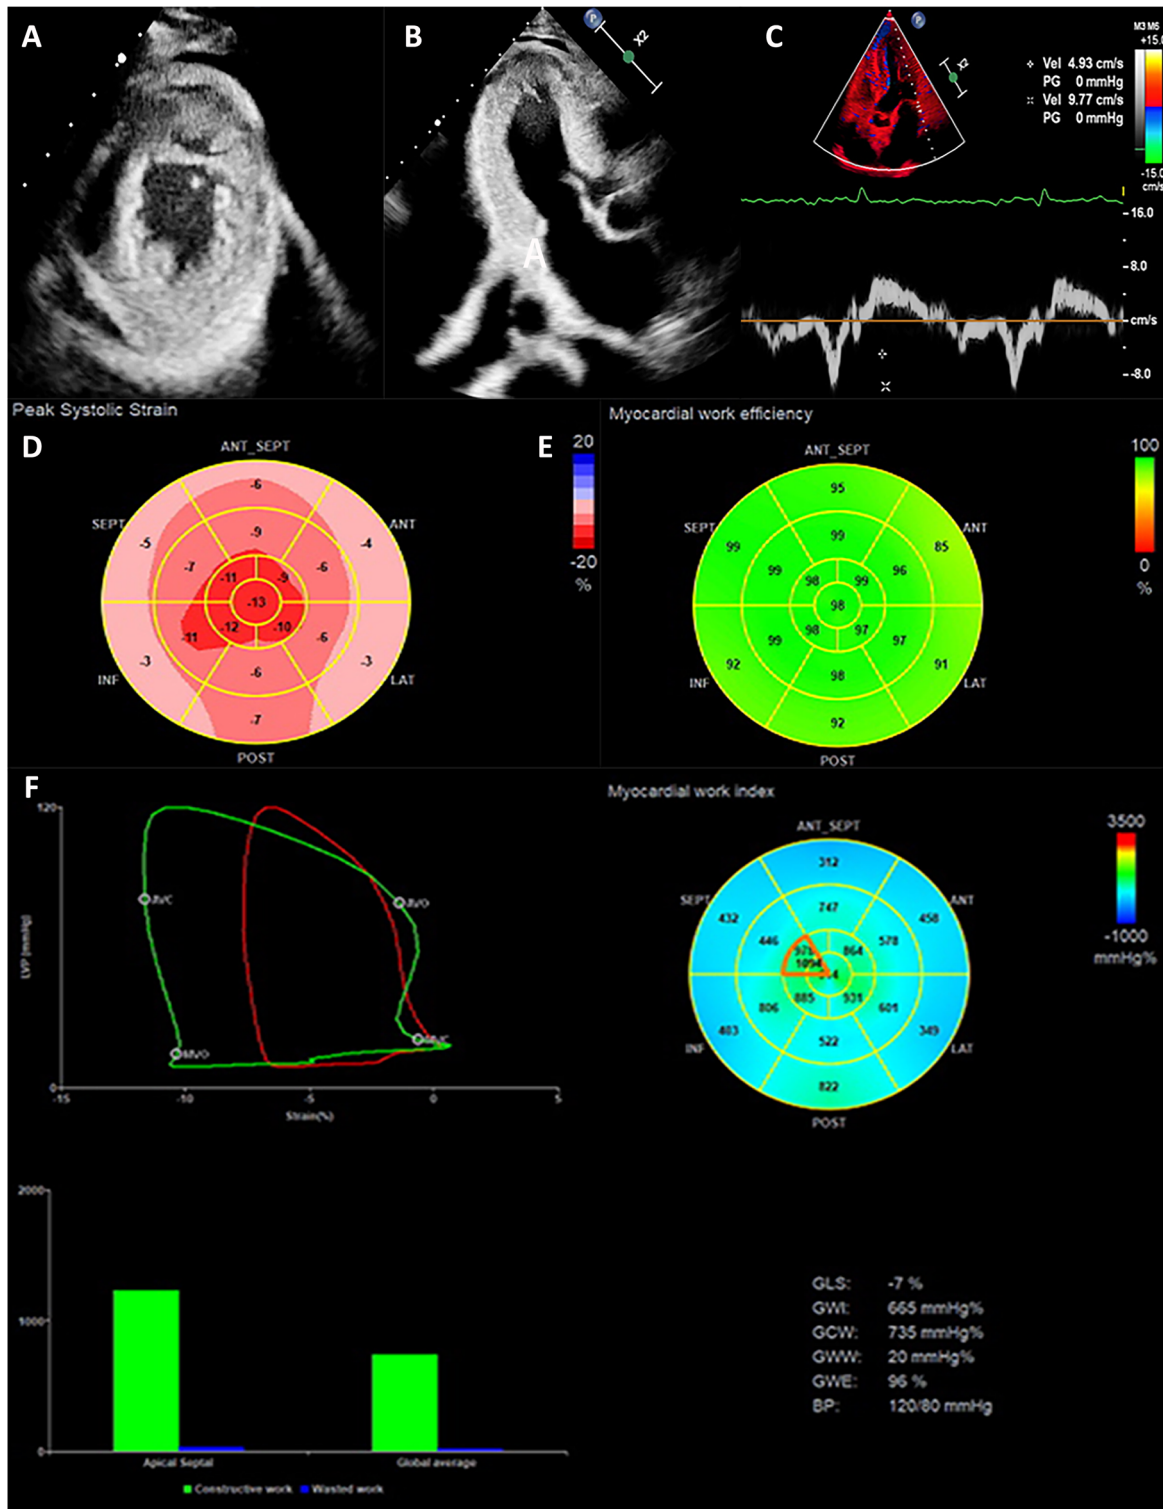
Application of Echocardiography in CA. A The apical view of the two-dimensional echocardiography showed the ventricular hypertrophy. B The three-chamber view of the two-dimensional echocardiography showed the hypertrophy and “granular” of the LV interventricular septal wall. C The tissue Doppler showed a decreased mitral
